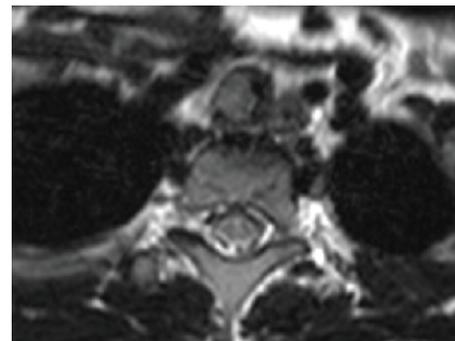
MRI examination after 2 months previous CT showed an iso intensity mass on T1WI, and a slightly high intensity mass on T2WI (Figure 2a).
